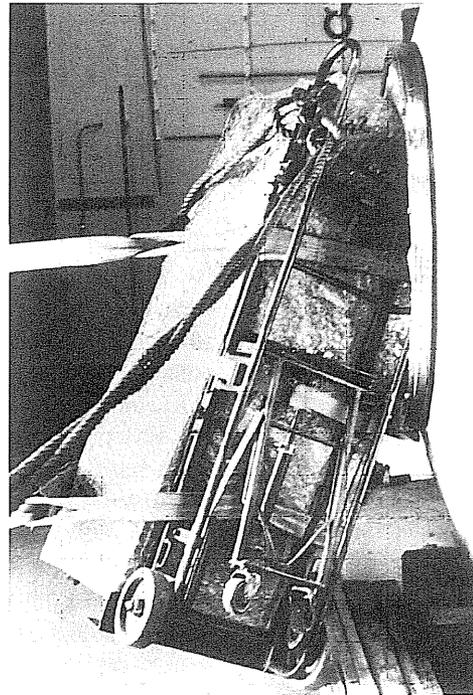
Ferromagnetic objects near MR scanners become projectiles. The primary safety risk in MRI scanning comes from the static magnetic field. External ferromagnetic objects brought within the magnetic field will become attracted to the scanner, accelerating toward the center of the bore. Shown are examples of a chair (A), floor buffer (B), oxygen canister (white arrow; C), and power supply (D), all lodged in the bores of MRI scanners. Projectiles present a severe risk to subjects within the scanner bore. (A,B courtesy of Dr. Moriel NessAiver; C from Chaljub et al., 2001; D from Schenck, 2000.)
